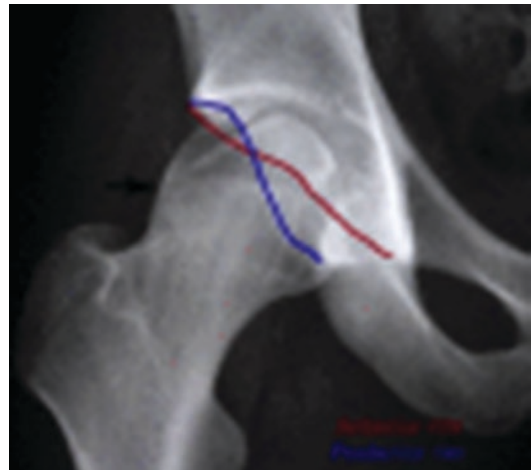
Preoperative AP pelvis radiograph showing a double-density shadow of a clamshell suprafoveal femoral head fracture seen after emergent closed reduction of anterior dislocation (Brumback type 4B). Note cam (arrow) and pincer FAI with focal acetabular overcoverage and crossover sign
